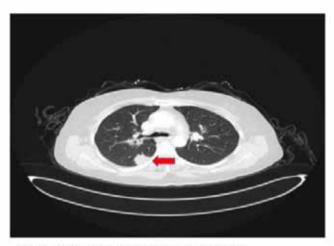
CT image of the nodule showing hypermetabolic activity in the right lung is observed.
